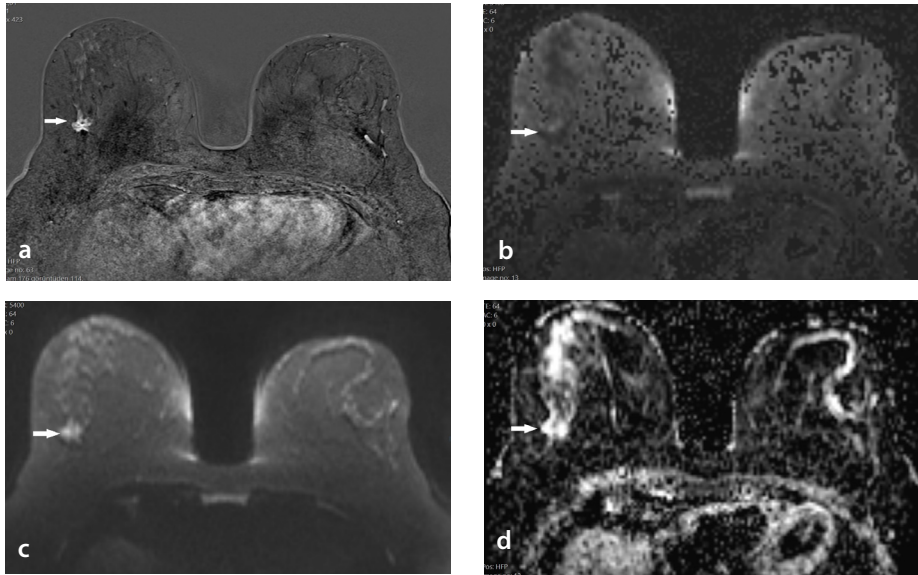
A 42-year-old female patient with a diagnosis of stromal fibrosis in the outer part of the right breast was observed. Structural distortion was observed on routine annual mammography and MRI was suggested. In the dynamic contrast-enhanced image (a), there was an enhanced lesion with an irregular shape, which indicates malignancy. The synthetic diffusion-weighted image (b) showed lesion isointense. The conventional diffusion-weighted image (c) showed a hyperintense signal but when DWI was evaluated with an ADC map (d) there was no diffusion restriction in the lesion. The average ADC value was $1.429 \times 10^{-3} \text{ mm}^2/\text{sec}$, which is above the cut-off value ($1.189 \times 10^{-3} \text{ mm}^2/\text{sec}$). MRI, magnetic resonance imaging; DWI, diffusion-weighted imaging; ADC, apparent diffusion coefficient.
